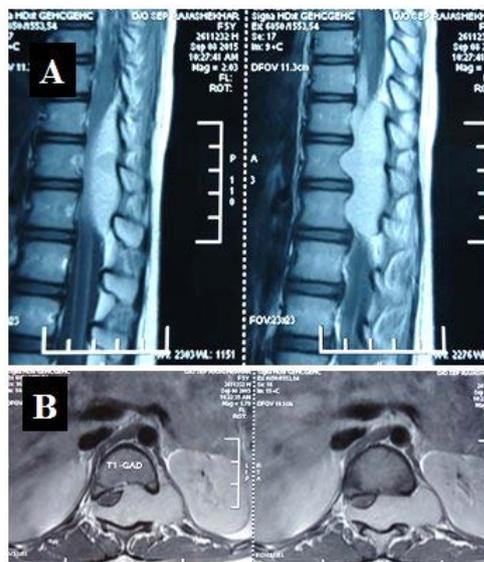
Pre Op Contrast MRI. Sagittal (A) and axial (B) images showing the extradural tumor with transforaminal extension
